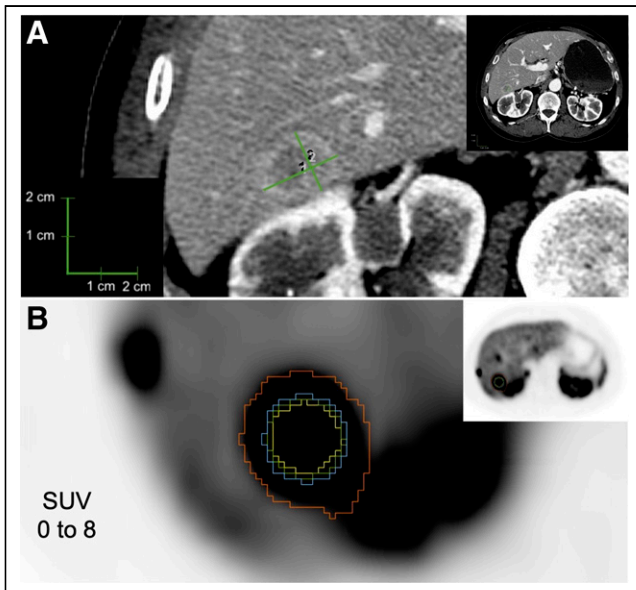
Example lesion 1. (A) CT evaluation of lymph node, with longest diameter of 2.2 cm (1) and longest perpendicular diameter of 1.3 cm (2). (B) PET evaluation of lymph node, with yellow representing 50% threshold segmentation; green, 42% threshold segmentation; blue, manual segmentation; and red, BSL segmentation.
